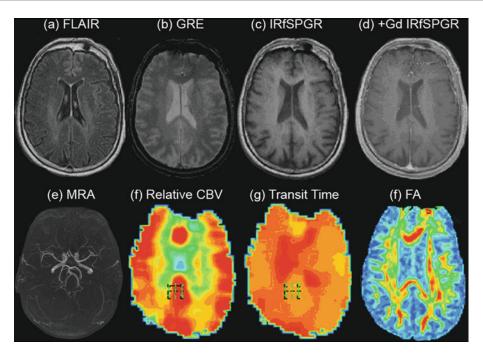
High-field MRI HTN Protocol (a) FLAIR, (b) gradient recalled echo, (c) inversion recovery fast spoiled gradient recalled echo in steady state, (d) postintravenous gadolinium as in (c), (e) 3D time-of-flight MR angiogram, (f) perfusion map of relative cerebral blood volume, (g) perfusion map of tissue transit time, and (h) fractional anisotropy (FA) map derived from the diffusion tensor imaging.
